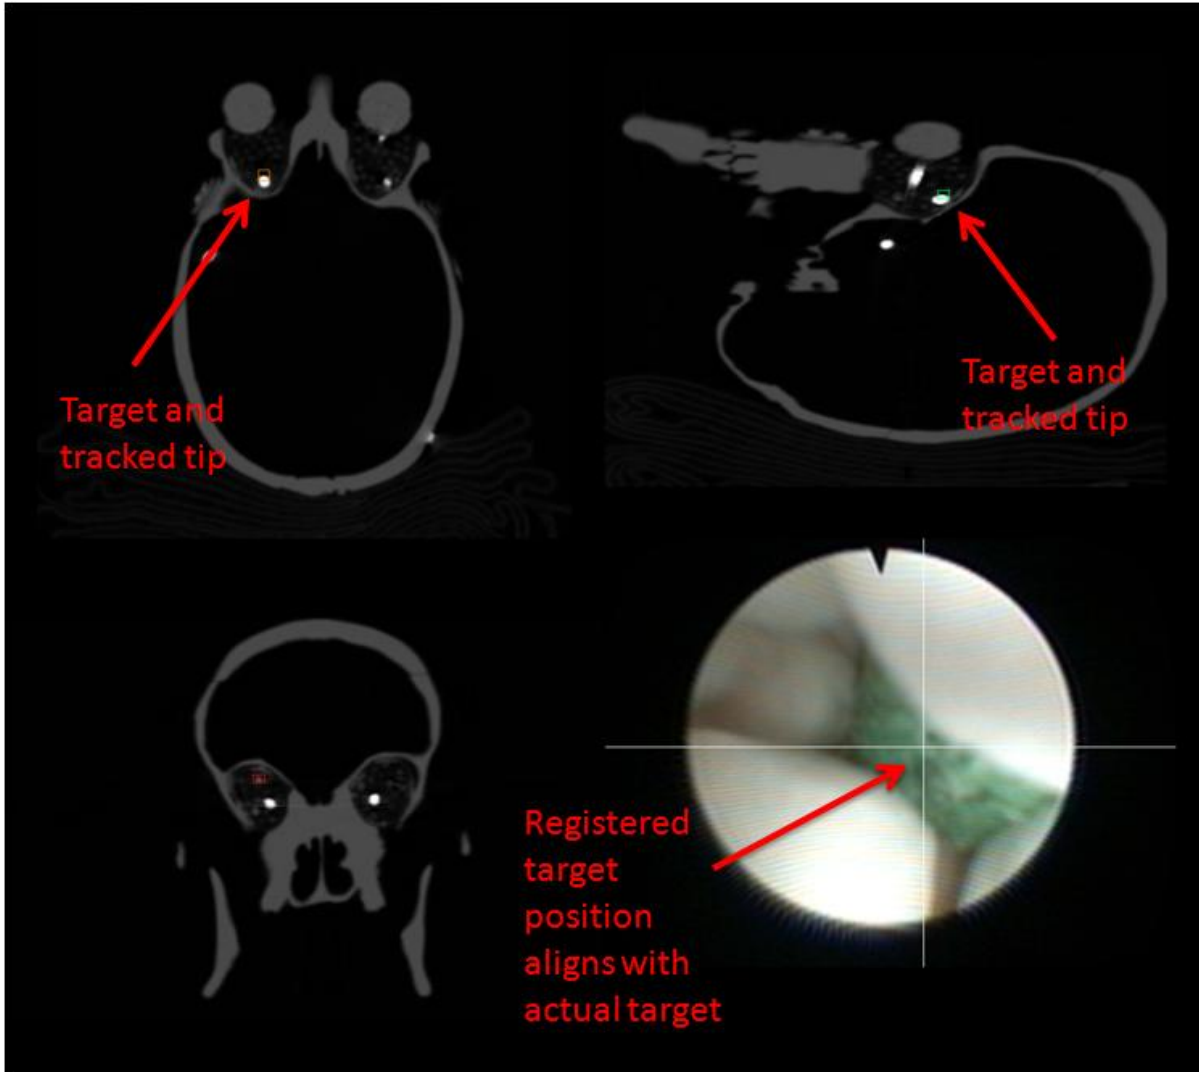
Correct target identification with video augmentation. The radio-opaque ball can be seen in the sagittal and transverse slices as the round bright spot. The small boxes in the CT images represent the registered position of the endoscope tip. The intersected lines on the endoscopic video frame indicate the location of the target.
